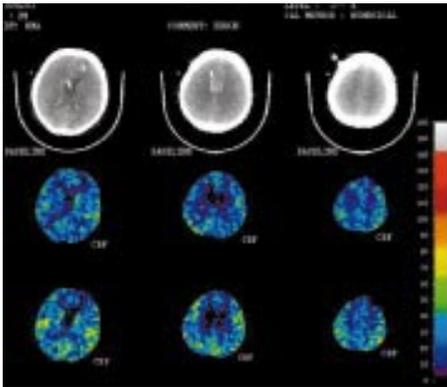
Xenon CT quantified cerebral blood flow scan in a poor grade (WFNS grade 5) patient showing critically low levels of cerebral blood flow.
